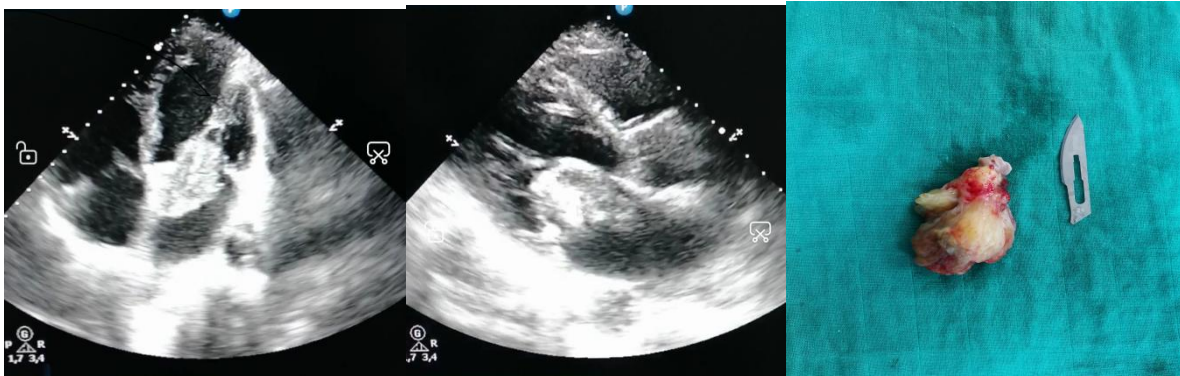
Transthoracic echocardiography showing a large left atrial myxoma protruding into the left ventricular cavity across the mitral valve Figure 3: the excised tumor in one piece
